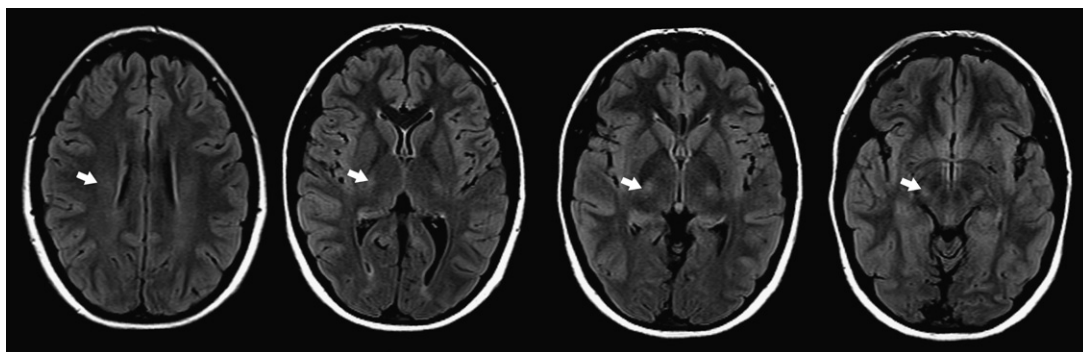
Axial FLAIR images in a normal 14-year-old boy show that the corticospinal tract is mildly hyperintense, as marked with white arrows.
